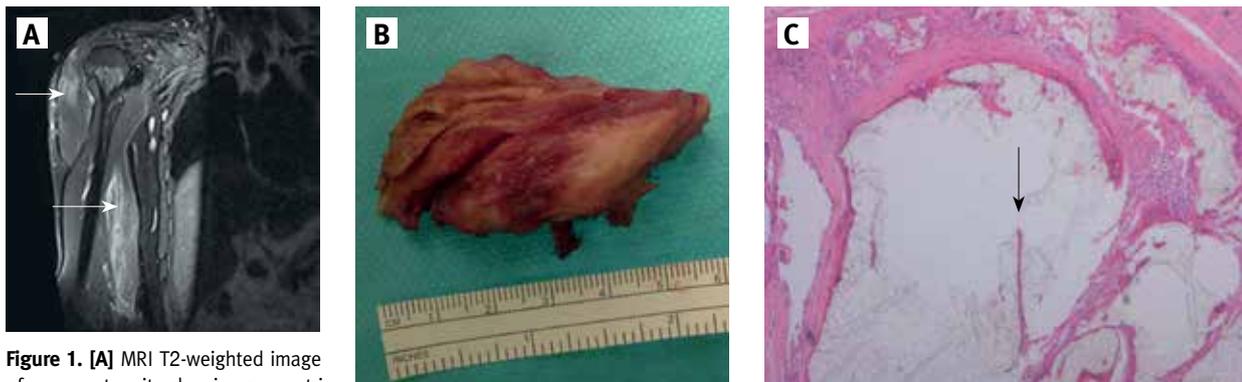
[A] MRI T2-weighted image of upper extremity showing symmetric hyper-intense STIR signal suggestive of inflammation within the deltoid, biceps and triceps muscles
